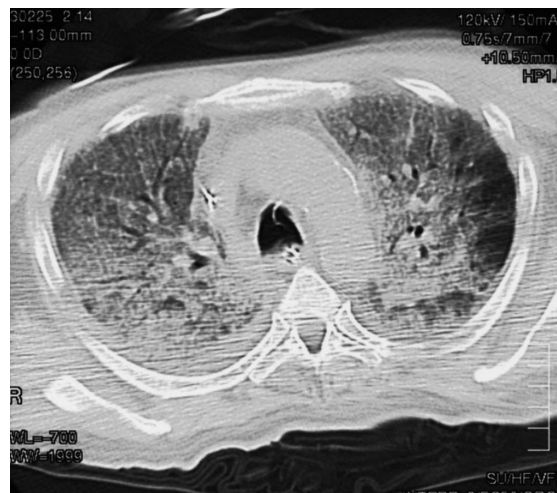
Chest CT on admission demonstrated severe interstitial pneumonitis in both lungs.
